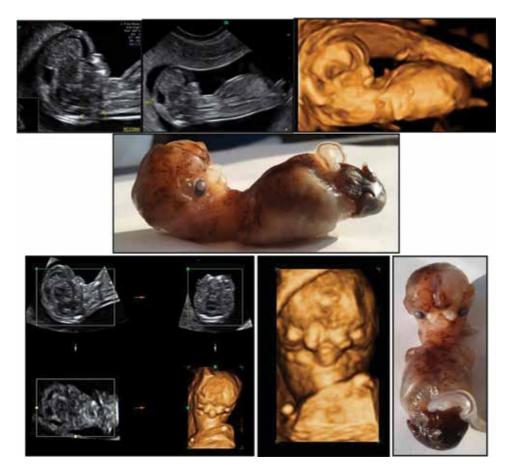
A rare case of complex severe facial malformation, in association with tetraamelia. The 2D conventional ultrasound, the 3D static surface rendering mode, and the pathologic data are correlated.
